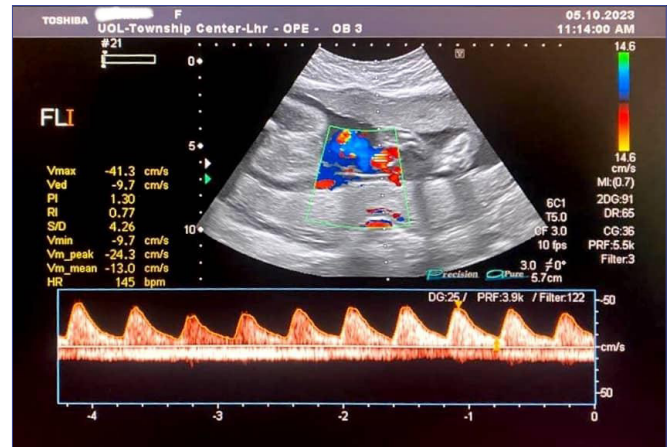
Doppler indices of umbilical artery of diabetic pregnant woman with gestational age of 30 week 0 day.
